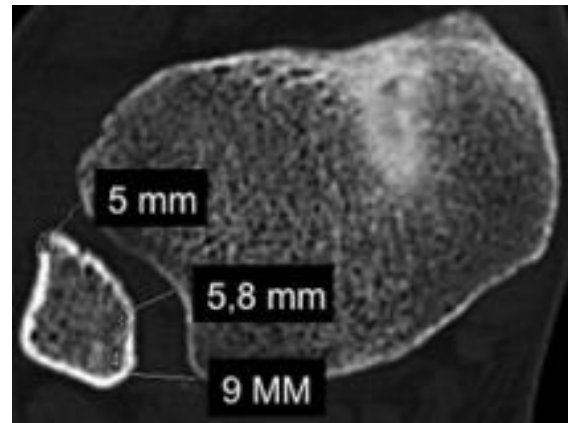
CT scan measuring anterior, medial, and posterior gaps (1)
